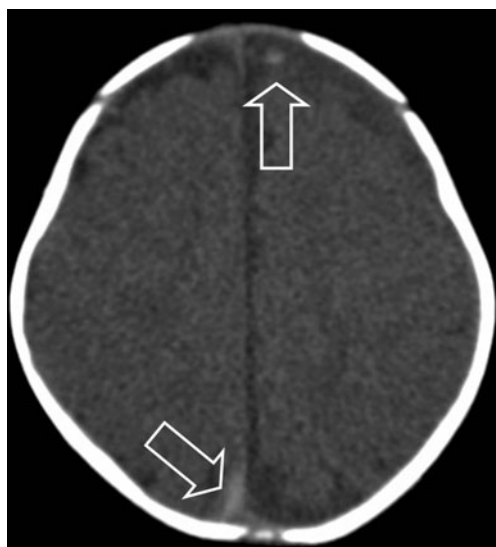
Case 1. Axial CT image of a 5-month-old boy who fell from a carrycot. *Information not available to the participating radiologists:* the boy was brought to the emergency department after a trauma with immediate neurological signs. The clinical history later changed into an abusive incident. The CT scan was performed 1 day after the incident. CT scan shows a left frontal and right posterior SDH (*open arrows*)
